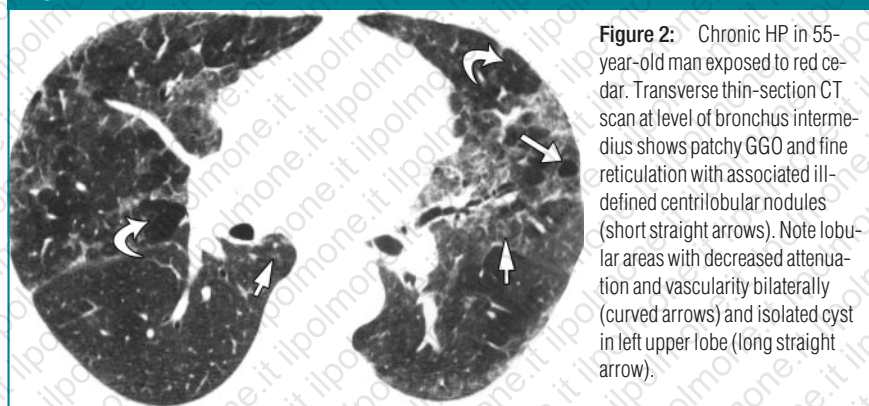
Chronic HP in 55-year-old man exposed to red cedar. Transverse thin-section CT scan at level of bronchus intermedius shows patchy GGO and fine reticulation with associated ill-defined centrilobular nodules (short straight arrows). Note lobular areas with decreased attenuation and vascularity bilaterally (curved arrows) and isolated cyst in left upper lobe (long straight arrow).
